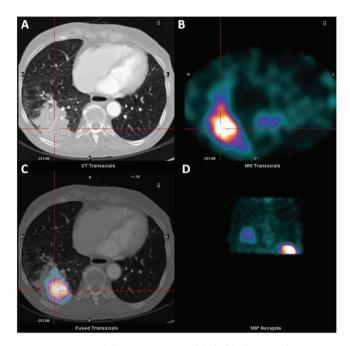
CT scan (A), Tc-99m-HMPAO-labeled leukocytes chest SPECT (B), fused Tc-99m-HMPAO-labeled leukocytes SPECT/CT hybrid image (C), and chest SPECT maximum intensity projection (D) on transaxial planes. SPECT images showed an area of clearly increased tracer uptake on the right inferior region of the chest, which was more evident in the delayed 24 h images. Fused Tc-99m-HMPAO-labeled leukocytes SPECT and CT scan of the chest demonstrated that the area of increased uptake corresponded with the soft tissue density mass (detected by CT scan) localized at the inferior lobe of the lung (Figure 1, 2). The hybrid SPECT/ CT fused images were crucial in order to achieve the right interpretation of this case (4), thus enabling the taken of an informed decision regarding the diagnosis of the presence of a lung abscess localized exactly in correspondence with the known lung cancer region. Therefore, the presence of SCV catheter infection was safely excluded. A proper match between the CT densitometric alteration and the pathologic Tc-99m-HMPAO-labeled leukocytes uptake in the inferior lobe of the right lung was clearly evident.
